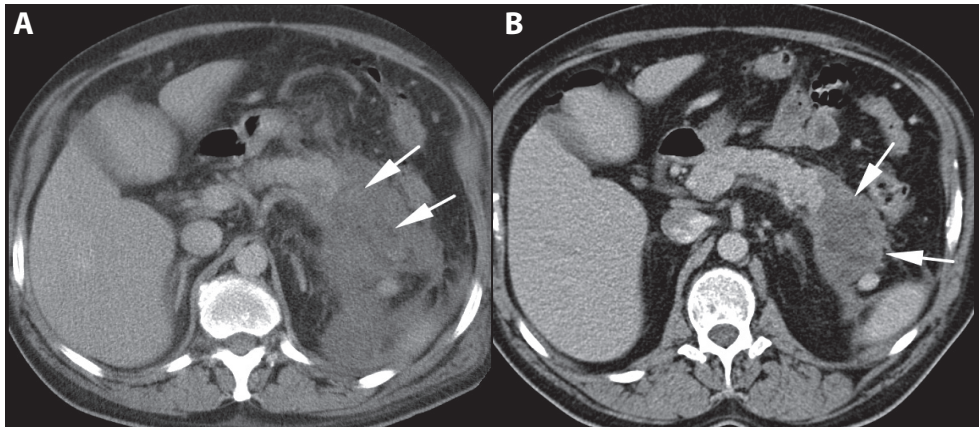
Left sided necrosis – pattern 3. (A) CT shows an area of necrosis at the pancreatic tail with associated necrotic collection in the left retroperitoneal space (arrows). (B) Follow-up CT at day 24 shows stable non-enhancement of pancreatic tail with associated heterogeneous necrotic collection (arrows) which has diminished in size.
